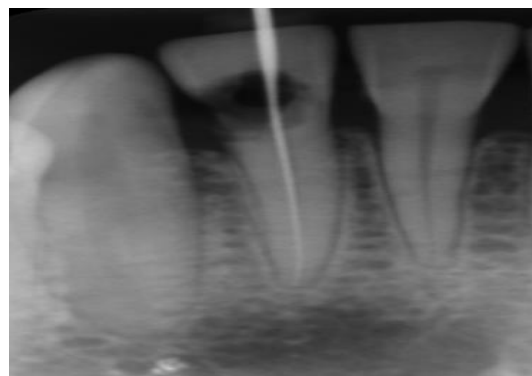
INTRA ORAL PERIAPICAL RADIOGRAPH
